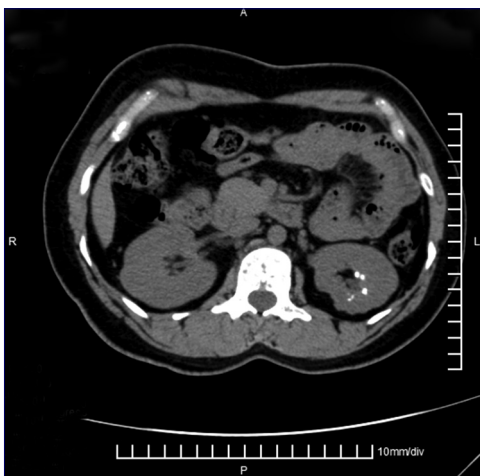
Unenhanced computed tomography showing left sided medullary nephrocalcinosis; note the right sided hyperplasia of the trunk as well as larger right kidney
